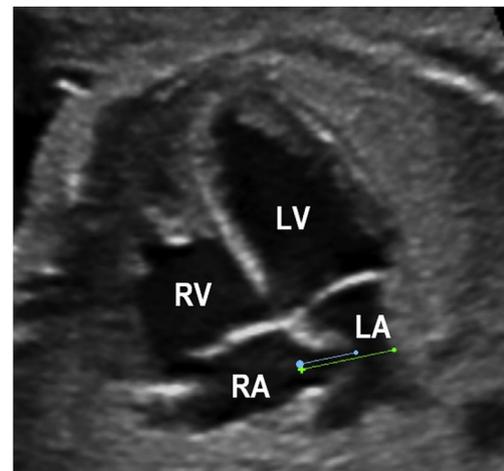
Fetal echocardiogram four chamber view of D-Transposition of the Great Arteries case at 26 5/7 weeks' gestation demonstrating features of a restrictive atrial septum including hypermobile atrial septum primum with increased bowing into the left atrium (LA) with an atrial excursion ratio of 60% (blue line represents deviation of the septum primum by 5.2 mm, green line represents left atrial length of 8.7 mm). RA, right atrium. RV, right ventricle. LV, left ventricle.
